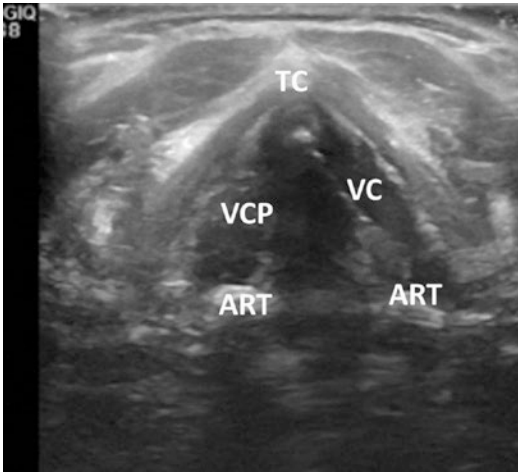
Transcutaneous ultrasound for vocal cord functional analysis demonstrating right vocal cord paralysis with vocal cord in the paramedian position (TC thyroid cartilage, VC vocal cord, VCP vocal cord paralysis, ART arytenoid) [Carneiro-Pla D, Miller BS, Wilhelm SM, Milas M, Gauger PG, Cohen MS, Hughes DT, Solorzano CC. Feasibility of surgeon-performed transcutaneous vocal cord ultrasonography in identifying vocal cord mobility: A multi-institutional experience. *Surgery*. 2014;156:1597–602]
